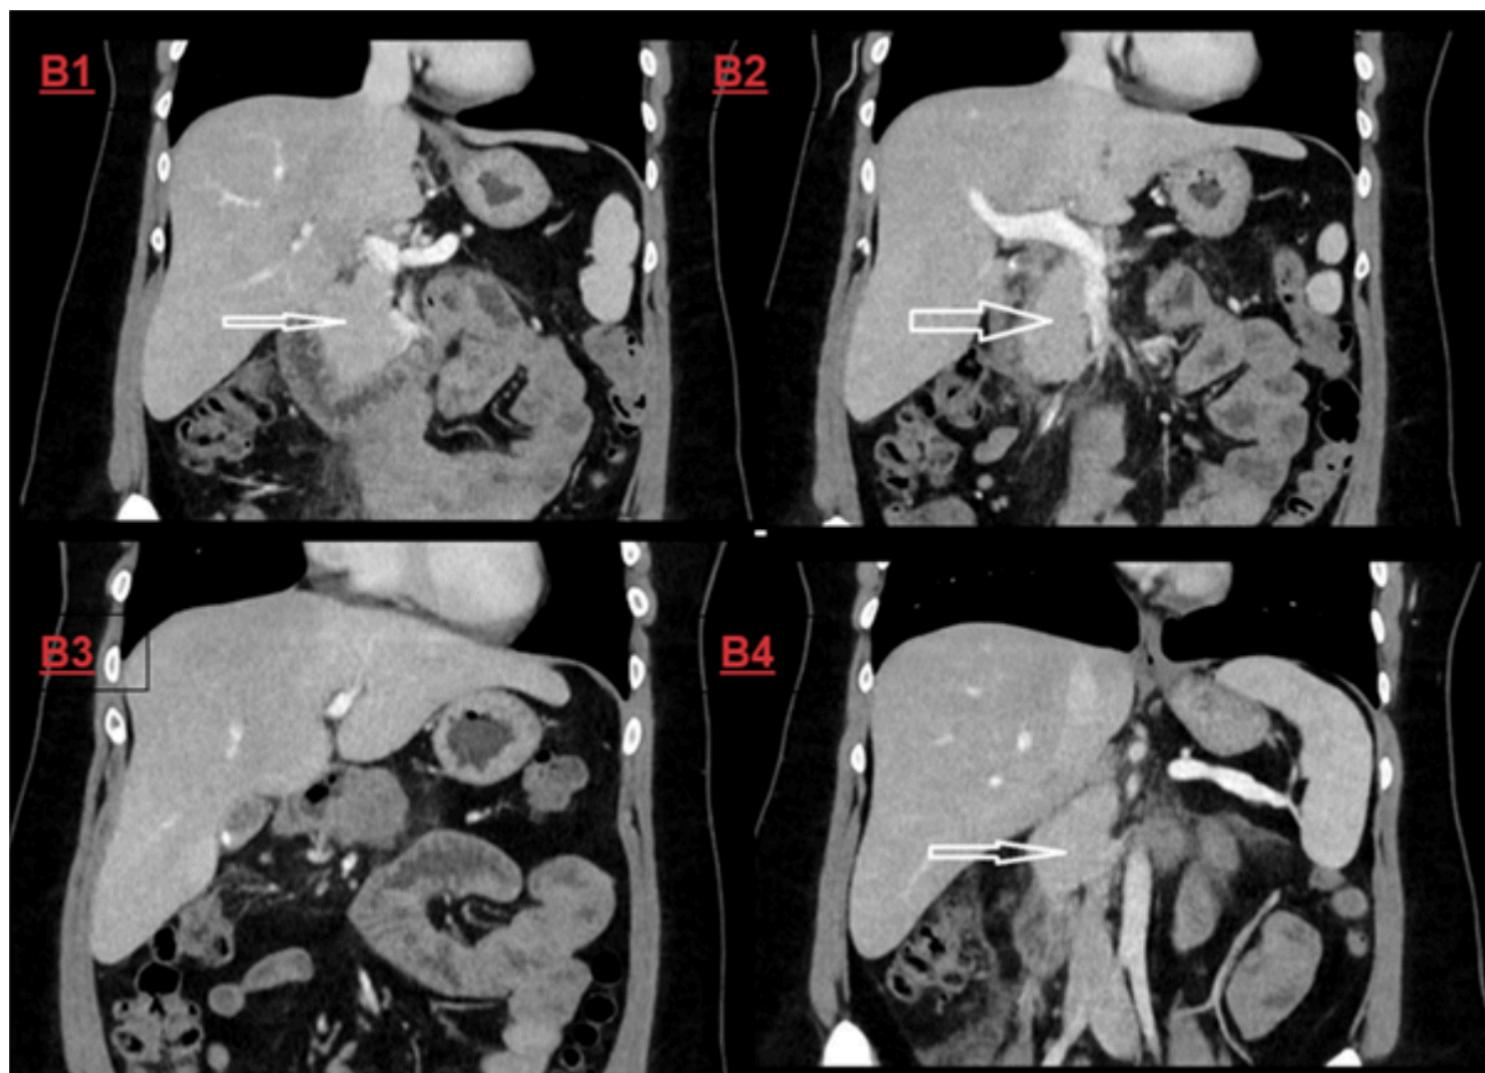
Contrast-enhanced computed tomography (CT) imaging of the abdomen in dorsal pancreatic agenesis. Coronal views, arterial phase (B1-B4). White arrowheads/arrows indicate the pancreatic head (ventral bud derivative), which represents the only residual pancreatic parenchyma. No body or tail structures are visualised; the splenic hilum abuts the stomach without intervening pancreatic tissue. No associated congenital vascular anomalies (e.g. preduodenal portal vein, splenic vein variants) or polysplenia/heterotaxy features are identified, consistent with isolated dorsal pancreatic agenesis.
